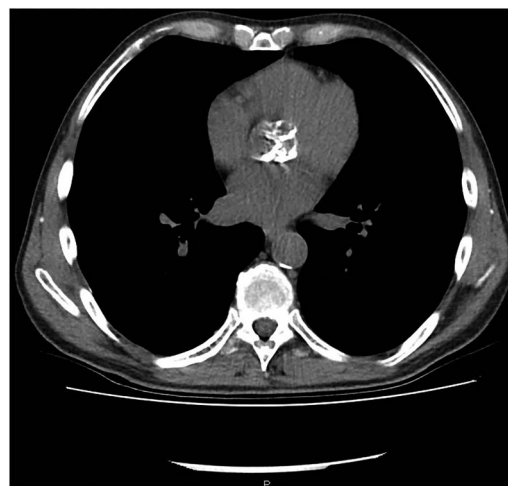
Same CT scan showing a heavily calcified aortic valve, most probably related to his previous hypercalcaemia.
